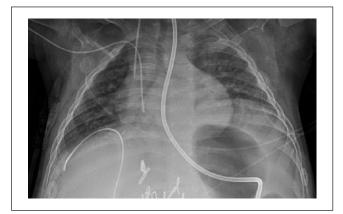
Chest X-ray showing bilateral decreased lung volumes with asymmetric elevation of left diaphragm.
